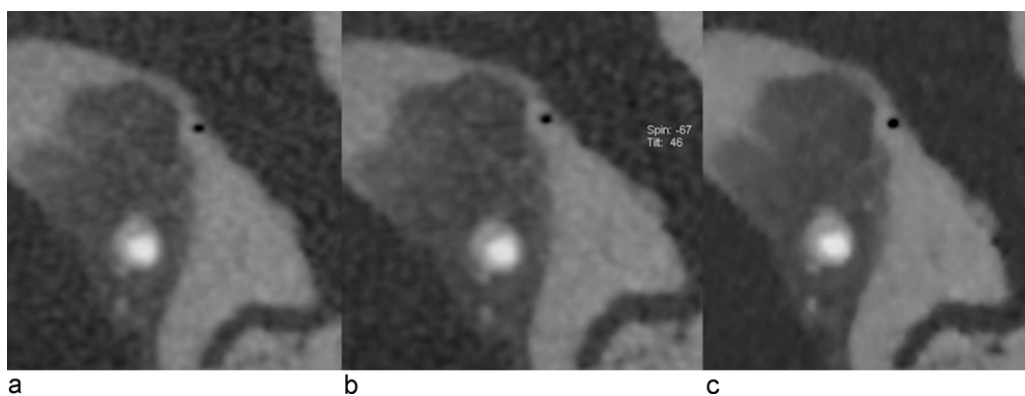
Cross-sectional CT images of a non-calcified coronary plaque.
